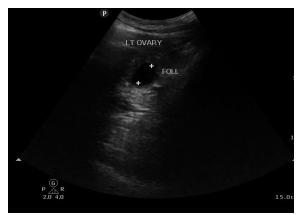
Ultrasound image showing dominant follicle in left ovary.
